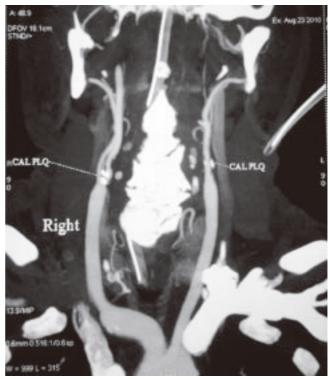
CT angiography coronal plane showing calcified plaque bilateral at right carotid bulb causing stenosis
